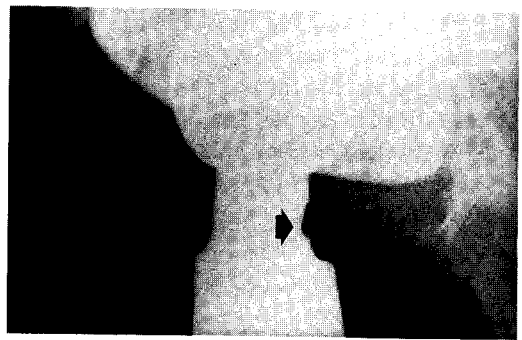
Lateral radiograph of the hip immediately postoperative from revision of acetabular component and head for impingement and recurrent dislocation. Retained femoral component is 3 years postoperative. Arrow identifies notched area of femoral neck secondary to impingement.
